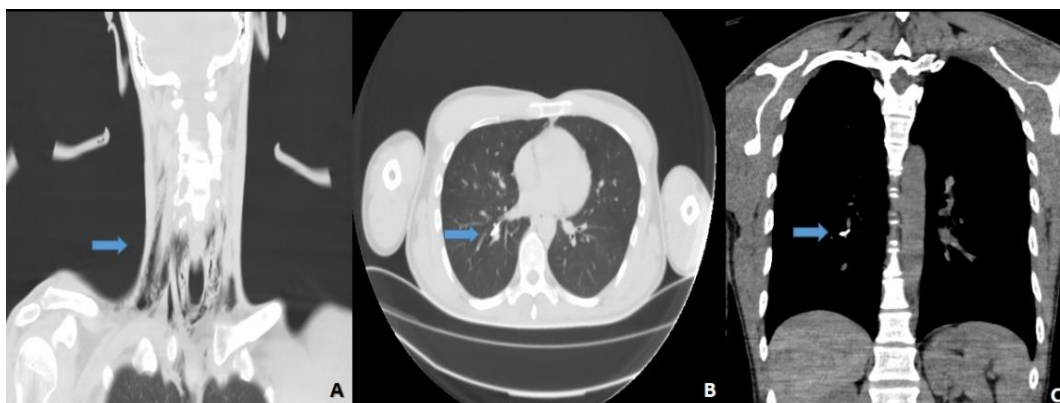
A: Cervical and anterior mediastinal emphysema on coronal cervical CT scan, marked with blue arrow.
